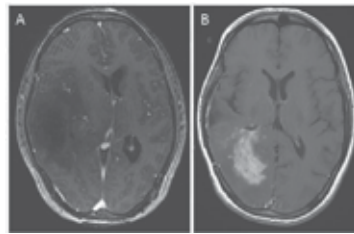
Serial imaging of malignant progression of glioma. A, T1-weighted MRI with contrast. Patient presented with headache. MRI revealed hypointense lesion in right hemisphere. Note edema and mass effect but lack of contrast enhancement. Pt underwent gross total surgical resection and pathology revealed grade II astrocytoma. B, T1-weighted MRI with contrast. Subsequent imaging revealed recurrent tumor seen as a contrast enhancing lesion in the previous resection cavity. Pathology revealed progression to grade IV astrocytoma (GBM).
